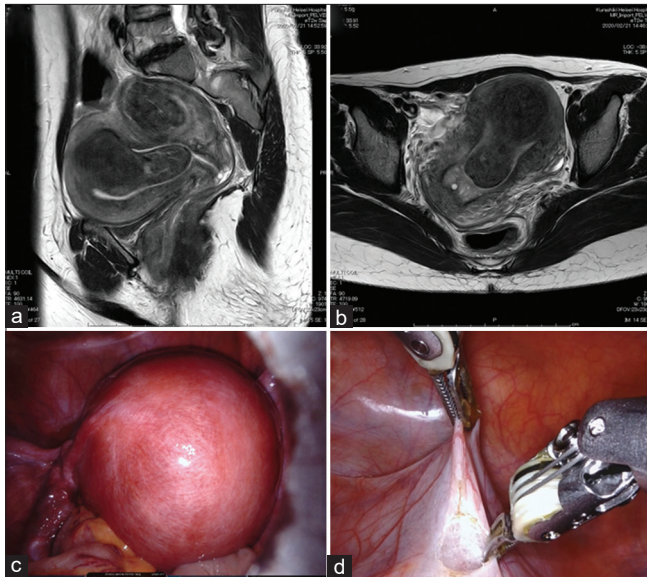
(a and b) T2-weighted sagittal (a) and transverse (b) magnetic resonance images. (c) Laparoscopy showing an enlarged uterus in the abdominal cavity. (d) Photograph showing the cutting of the vesicouterine peritoneum using the double bipolar method
